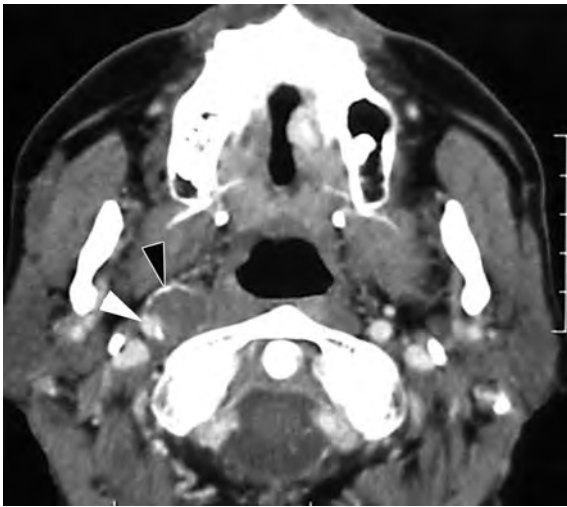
Axial contrast-enhanced CT-image shows nodular lesion in the retrostyloid compartment of the PPS. At first sight one may think about retropharyngeal adenopathy. However, the narrowed lumen of the internal carotid artery (*white arrowhead*) is within the peripheral part of the mass, which also shows some peripheral calcifications (*black arrowhead*): these findings are compatible with an internal carotid artery aneurysm
